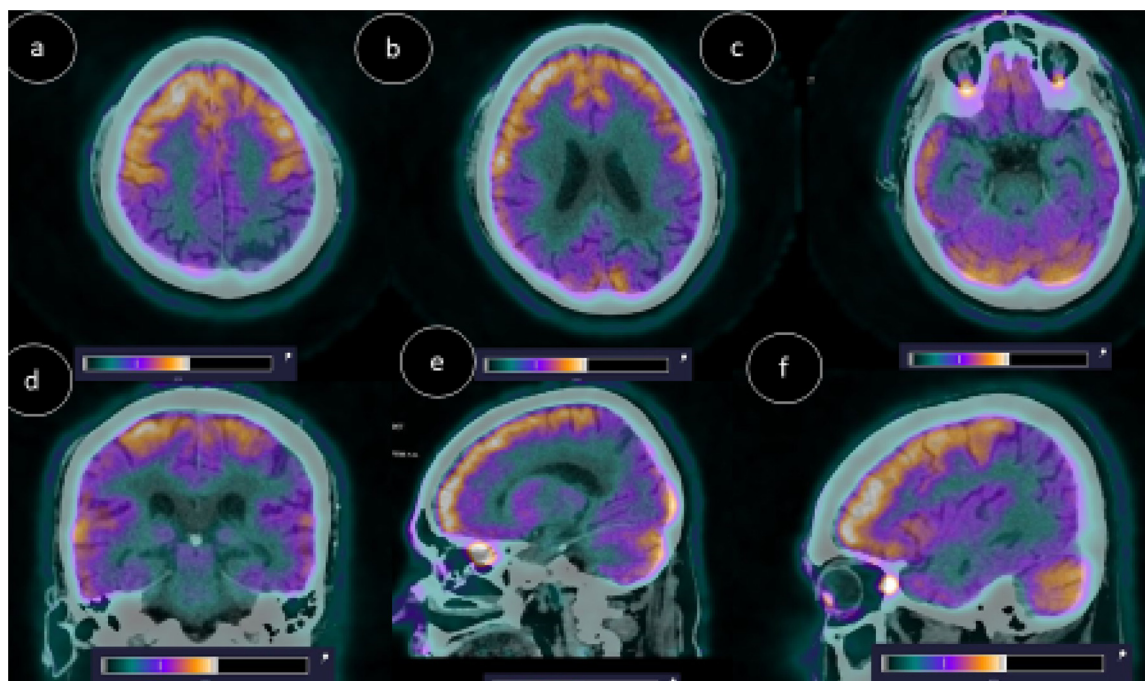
Fused F18 FDG PET CT images show a. Asymmetric decrease in tracer uptake involving the parietal lobes involving the inferior parietal, supramarginal and angular gyrus (left > > right) b. posterior cingulate gyrus c, d. bilateral temporal lobes (left > > right) involving the parahippocampal gyrus, hippocampus and amygdala, e and f, precuneus (left > > right), cuneus, also involving middle and inferior occipital gyrus on the left side.
